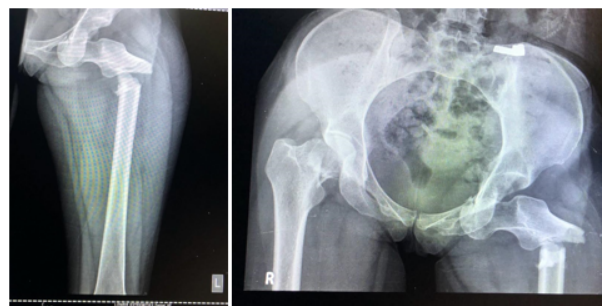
18 month follow-up x-ray
